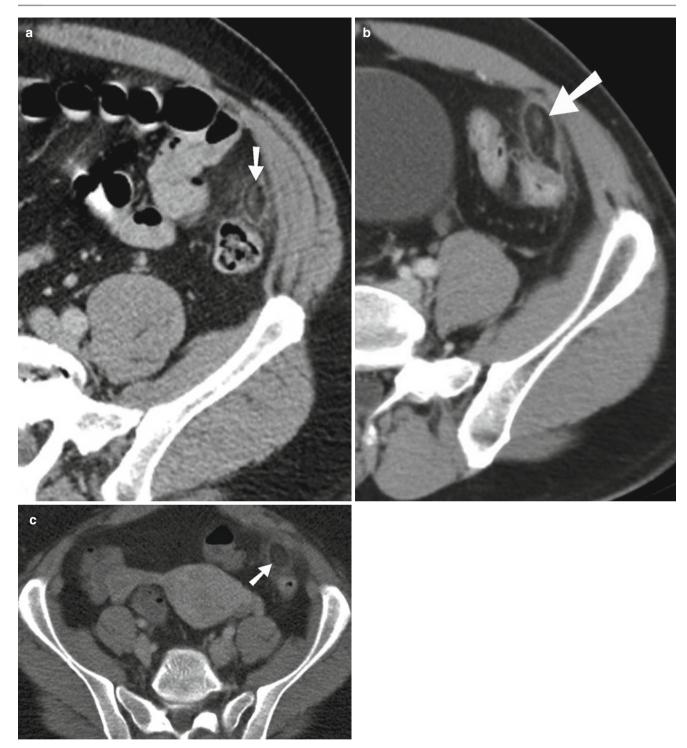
Acute epiploic appendagitis. (a-c) CT study demonstrates inflamed epiploic appendage (*arrows*) in the left lower quadrant. The central high density with the fatty lesion represents thrombosed or congested vessel
